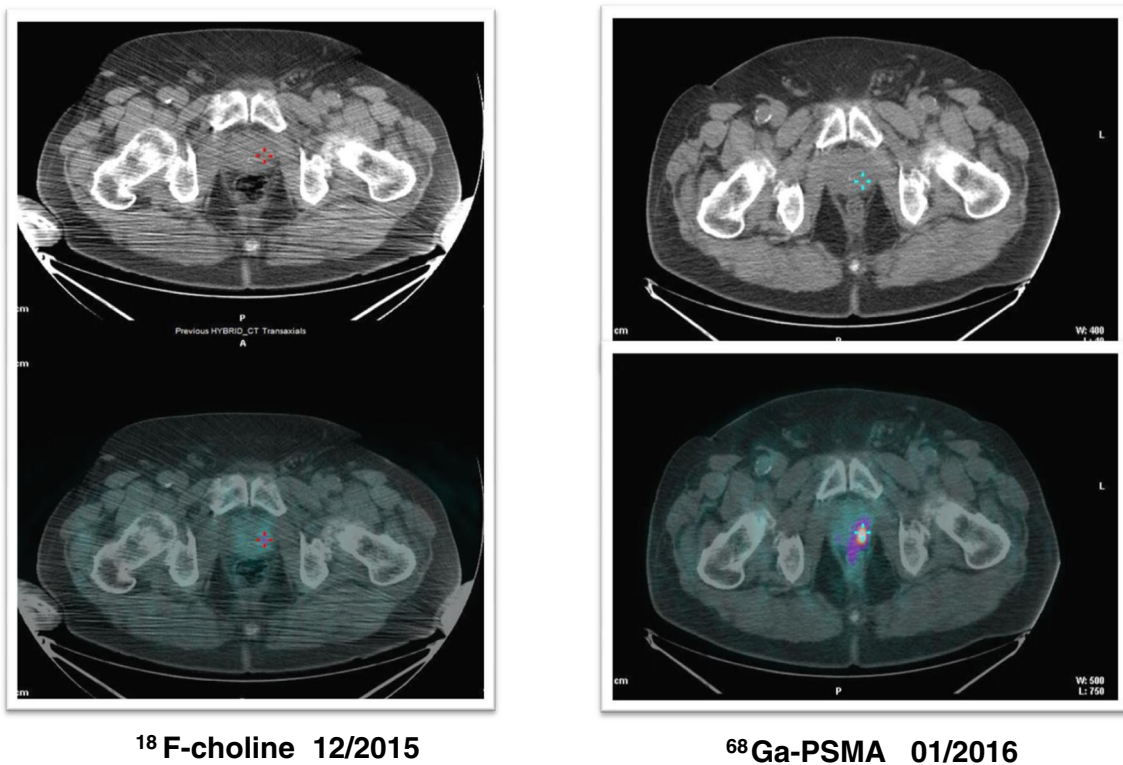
Comparison between choline and PSMA imaging
